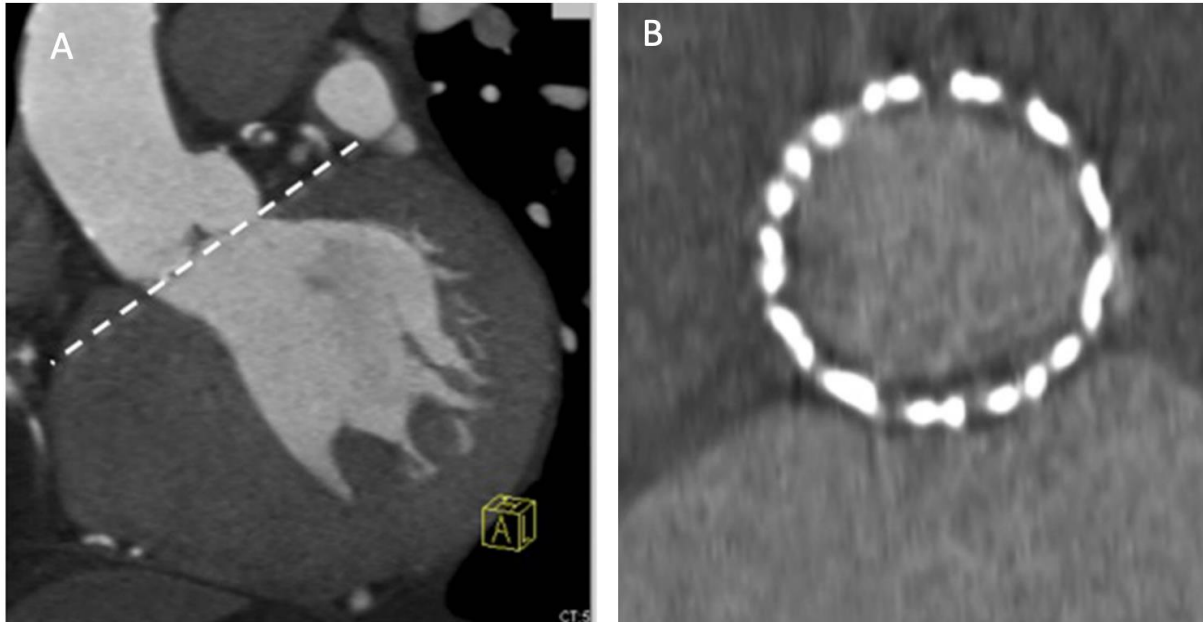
A) Aortic annular plane marked by the dashed lines. B) Post-implantation CT of the same patient showing the circular deployment of the prosthesis. (Reused with permission from Springer Nature publishing. Mohamed Marwan et al, Role of Cardiac CT Before Transcatheter Aortic Valve Implantation (TAVI). *Curr Cardiol Rep.* 2016 Feb;18(2):21. doi: 10.1007/s11886-015-0696-3)⁴³.
